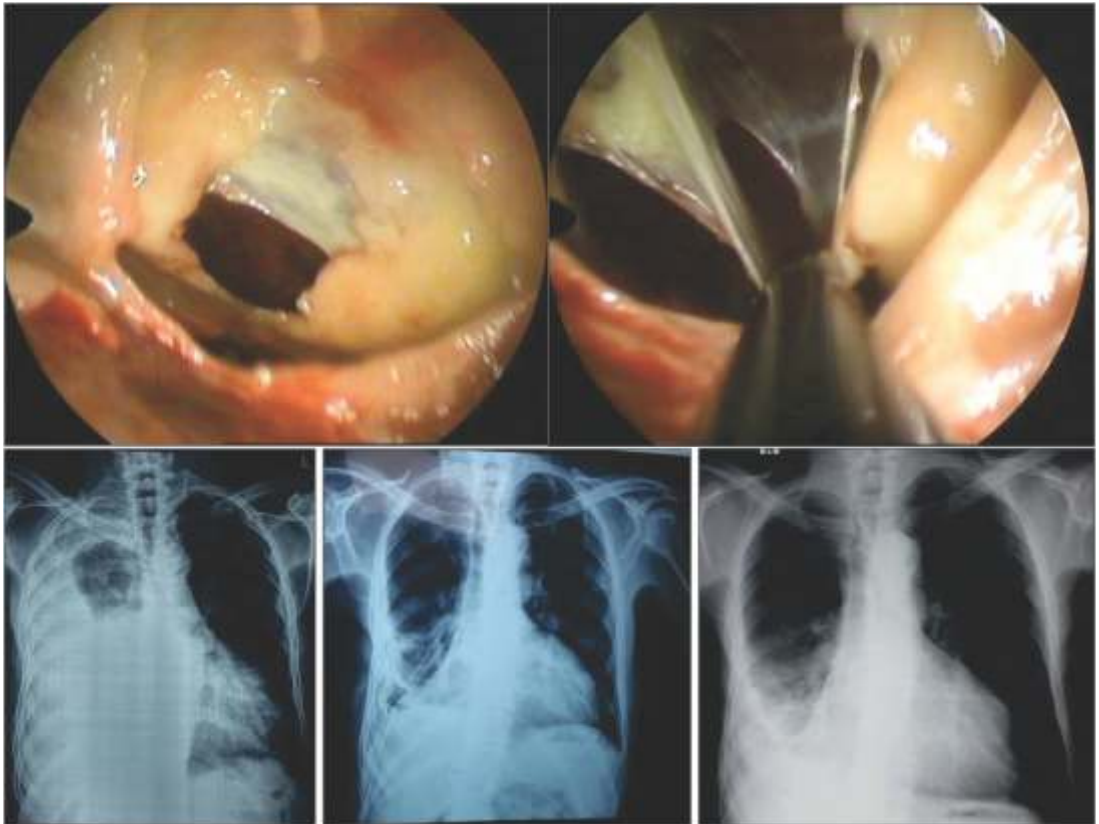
Top: Thoracoscopic images showing thick pleural adhesions (left) and adhesiolysis (right) in a 70-year-old male with thoracic empyema, having advanced renal disease and stable coronary heart disease (EF 30%); Bottom: Serial of chest radiographs of same patient with large multiloculated pleural effusion/empyema (left), post medical thoracoscopic adhesiolysis (middle) and follow up after 2 weeks (right) showing right lower zone opacity (pleural thickening on ultrasound).
